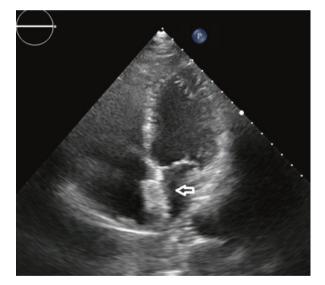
Post-procedural echocardiography showing the occlude device on IAS (arrow)
